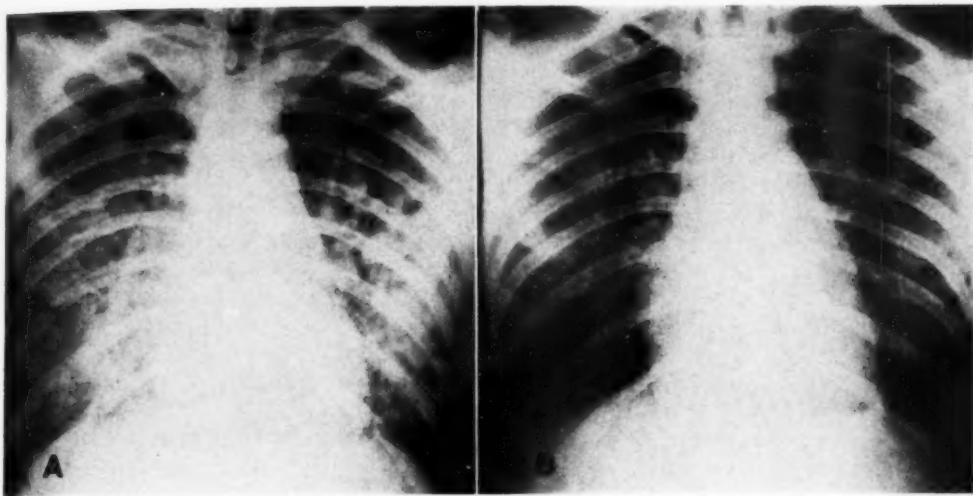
A. Roentgenogram (portable) of the chest showing numerous areas of increased density bilaterally, chiefly central in distribution and partially confluent on the left. The pulmonary vessels are slightly enlarged. Tenth day of illness.
